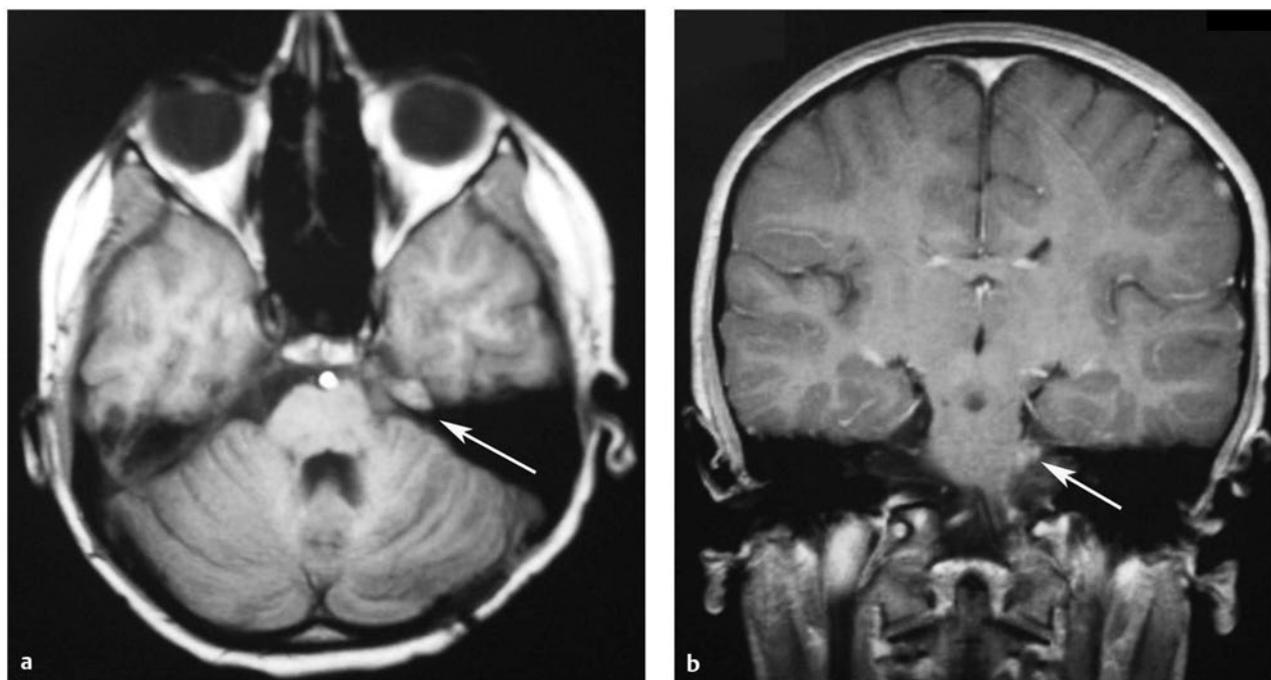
Asymptomatic, recurrent ependymoma discovered on routine imaging. (a, b) This child with previous gross total resection and radiotherapy of a posterior fossa ependymoma was followed with routine magnetic resonance imaging. An asymptomatic recurrence was found in the left cerebellopontine angle, adjacent to the brainstem (*white arrows*). This was resected, and the child was treated with focal radiotherapy.
